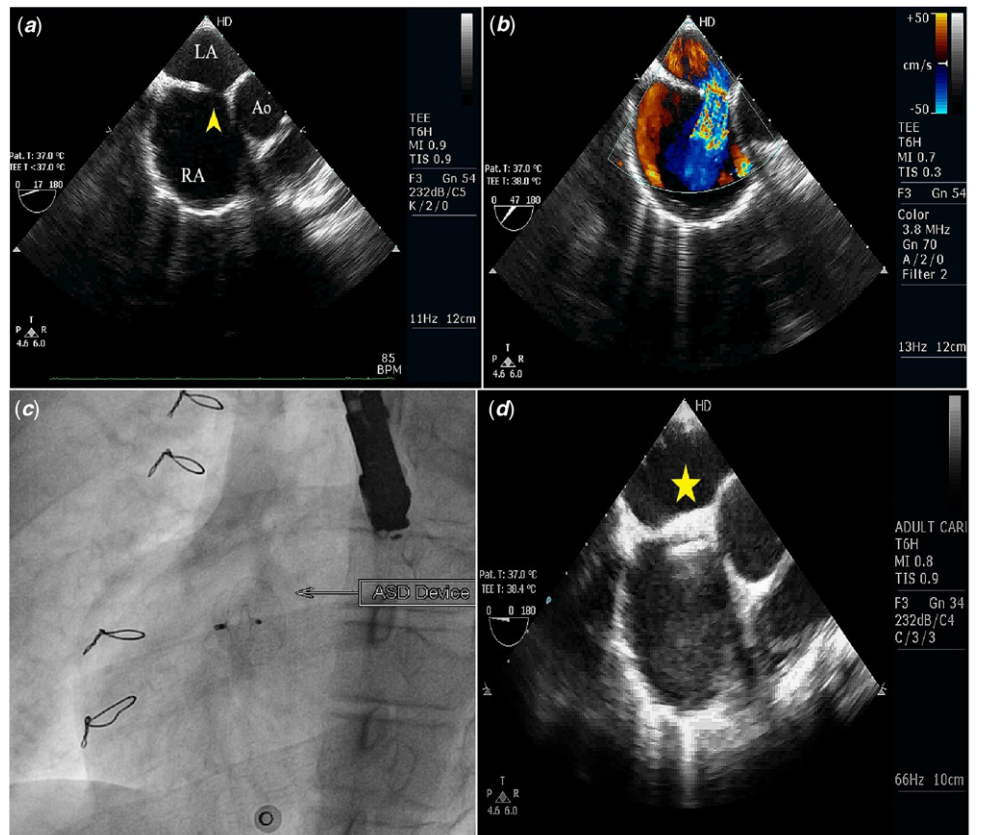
(a, b) TEE images showing 11 mm recurrent ASD (yellow arrowhead) in the pericardial patch with an absent aortic rim and with a left to right shunt on colour flow doppler. (c) Fluoroscopic image after successful Amplatzer ASD 14 mm device deployment. Sternal sutures suggestive of previous surgery can be seen. (d) TEE image indicating stable device position (yellow star) across the pericardial patch. ASD – Atrial septal defect; RA – right atrium; LA – Left atrium; RV – right ventricle; LV – Left ventricle; Ao- Aorta; TEE – Transoesophageal echocardiography; ASD – Atrial septal occluder.
